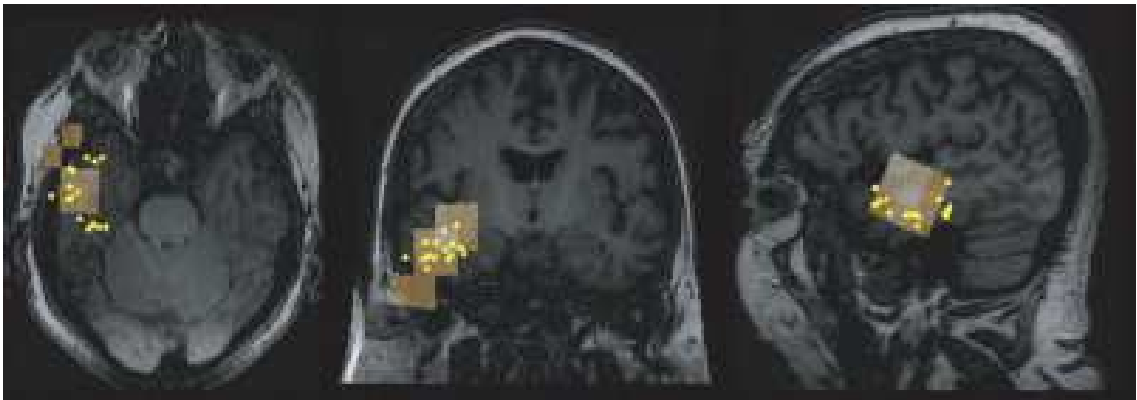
An example concave topology for single spike localizations with MEG. Single spike dipole localizations (yellow dots) and spike-locked beta/gamma activity localizations (squares) shown on individual MRI of a patient. Figure adapted from [190].
